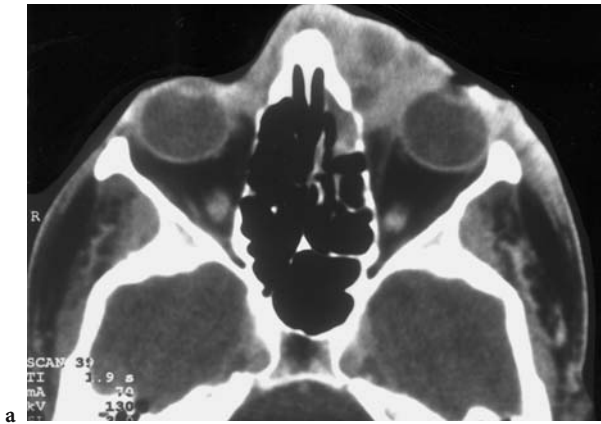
A 36-year-old man with acute inflammation of the left face, chronic dacryocystitis persisting for 3 months, and putrid exudation of the left lacrimal point. Diagnosis: chronic dacryocystitis with preseptal orbital and facial phlegmon. Contrast-enhanced CT: a axial view with inflammatory, partly necrotic infiltration of the inferior, medial, extraconal space in the region of the nasolacrimal duct. Note the presence of tissue in the rostral left ethmoid, but attenuated medial muscle and tendon. b Coronal view visualizing widening of the entrance and the left nasolacrimal duct (compared with the right [arrow]) due to inflammation, extending to the adjacent ethmoid cell. Note inflammation of the subcutaneous fat of the left cheek
